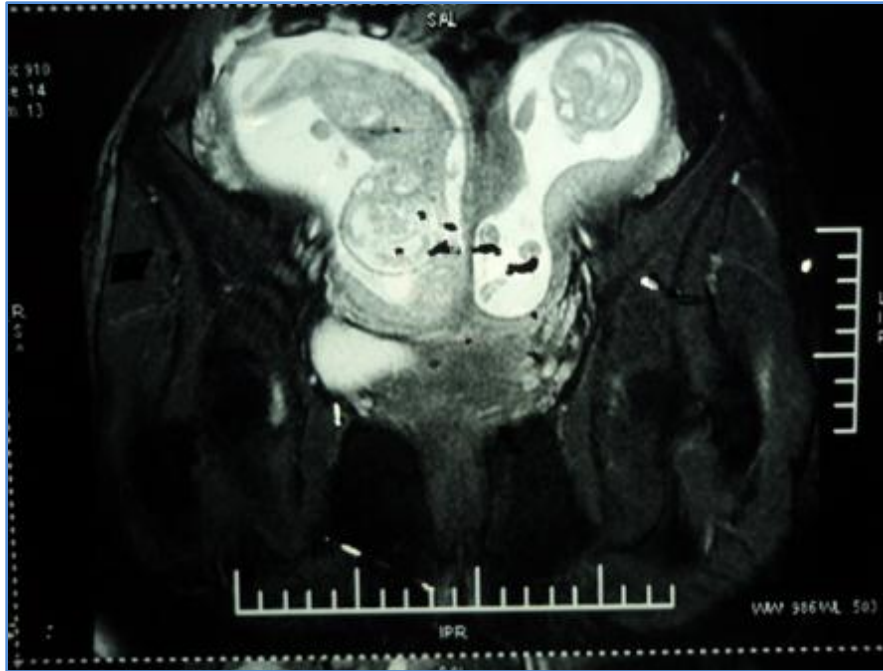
MRI SHOWING TWO UTERINE CAVITIES WITH TWO IUGS
